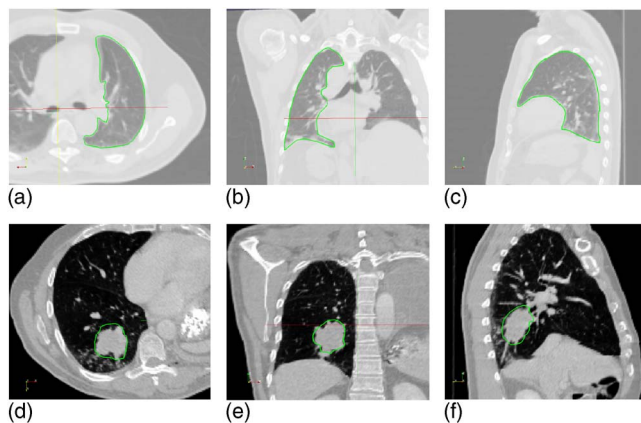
The template CT images and manually segmented contours for two lung cancer patients (top row: patient 1; bottom row: patient 3) on axial, coronal, and sagittal views. Right lung of patient 1 and GTV of patient 3 were manually delineated, respectively.
